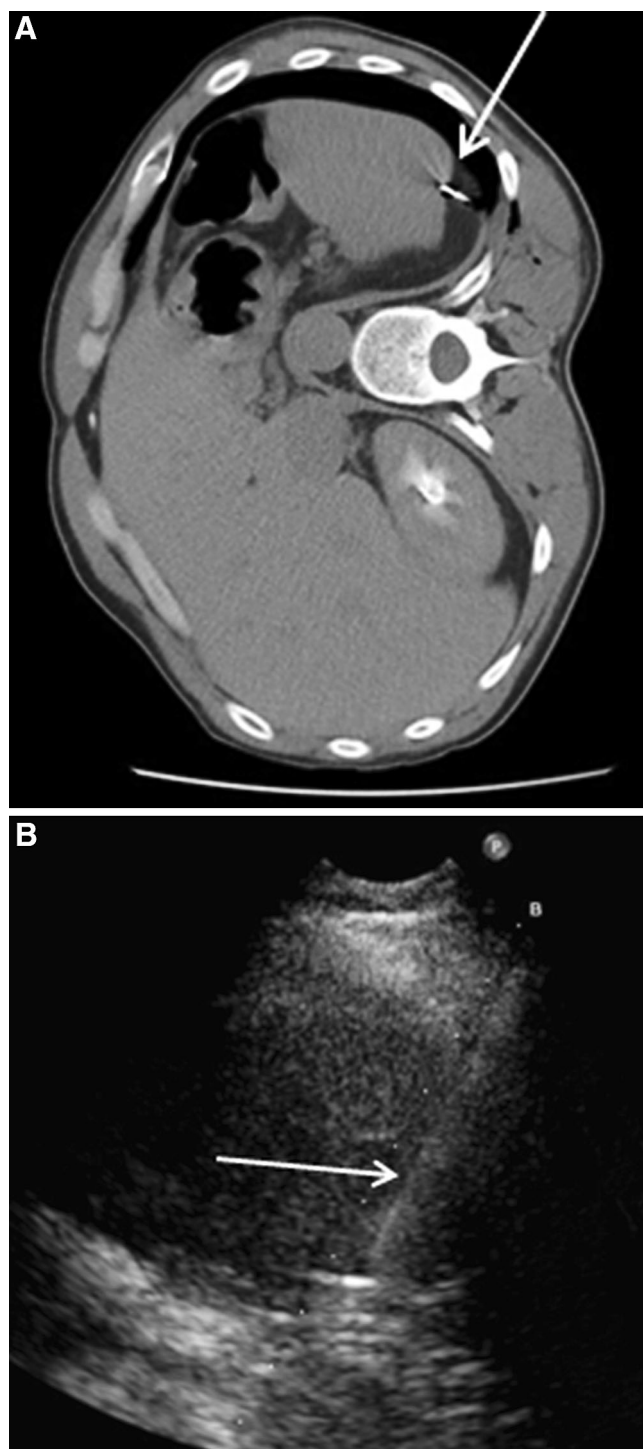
Image-guided splenic biopsies. A 59-year-old man with splenic lesion. Axial CT image shows a portion of the biopsy needle in the spleen (arrow); this was proven to be littoral cell angioma. B 54-year-old woman with incidental splenic lesion on CT. Ultrasound-guided biopsy was performed, with the needle (arrow) seen within the lesion.
